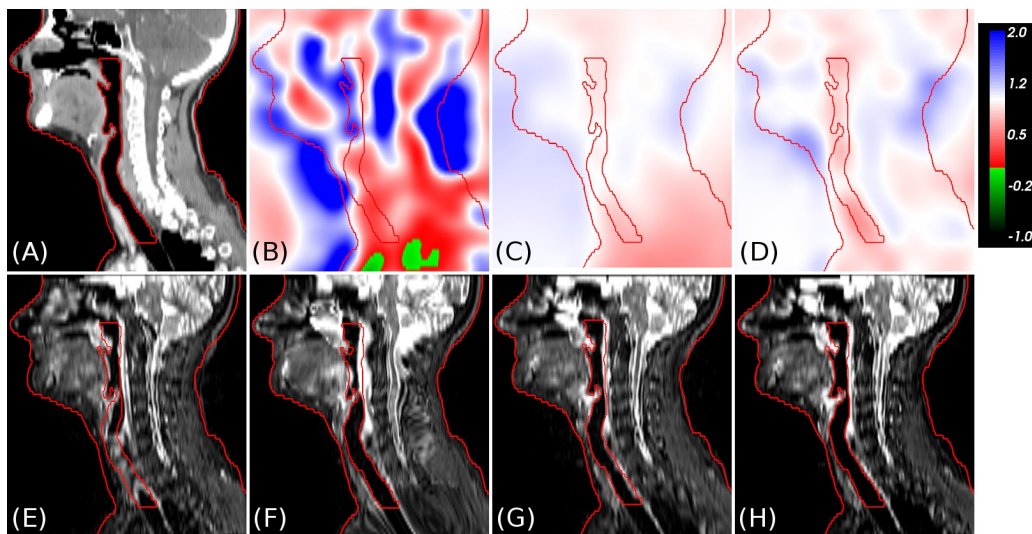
Map of Jacobian determinants (I_{JD}) and corresponding deformed MR from different registration methods for Patient 1. Original CT (A), I_{JD} from DR with GMI (B), GMI+BEP (C) and LMI+BEP (D). Transformed MR from RR (E), deformed MR from DR with GMI (F), GMI+BEP (G) and LMI+BEP (H). The structures skin and respiratory tract segmented on the original CT are shown as red contours.
